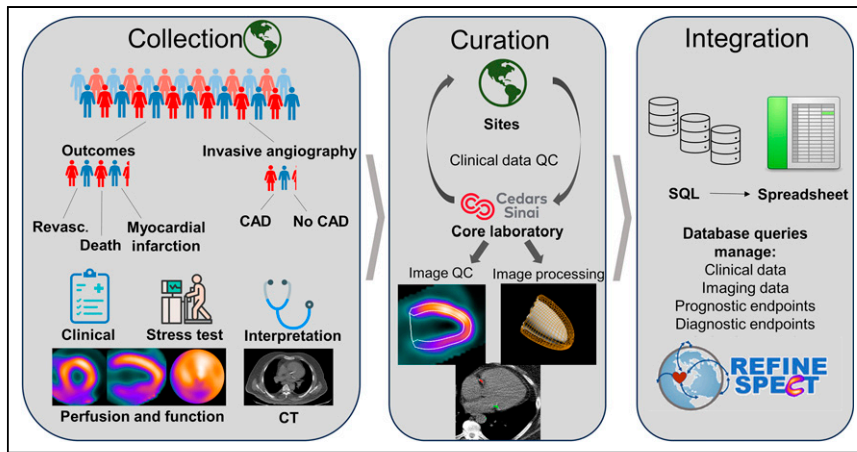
Overview of data acquisition and processing scheme for REFINE SPECT registry. Activities include clinical data and image collection, deidentification at participating sites, data transfer to core laboratory for further data-processing quality control in communication with sites, batch mode image quantification, and combined database integration. SQL = structured query language; QC = automatic quality control.
